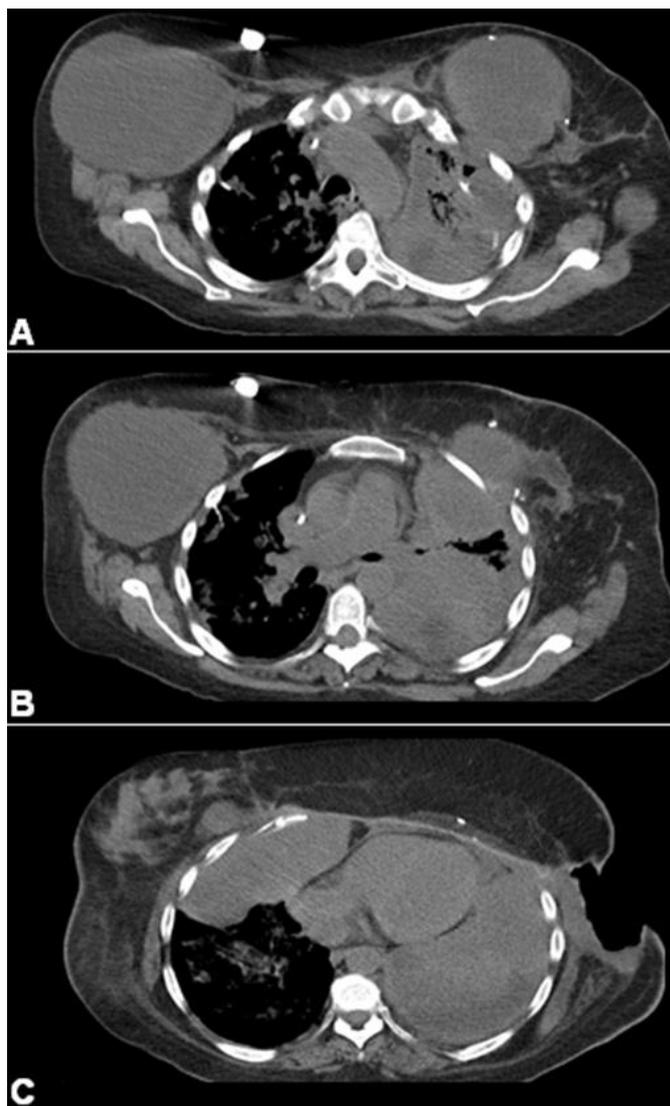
43 year old female with malignant phyllodes tumor. Non-enhanced chest CT. 305 mAs, 120 kVP, 1.5 mm slices.
